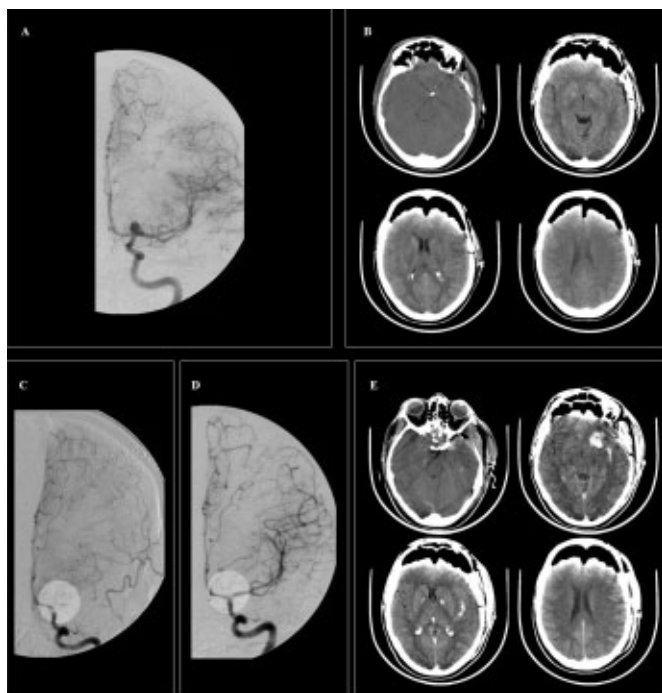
A) Cerebral angiography confirming the presence of an aneurysm of the left internal carotid artery ; B) Urgent post-operative CT-scan showing no hemorrhage or acute sign of ischemia. C) Immediate angiography showing a subocclusive thrombus in the left terminal ICA extending in the M1 segment and an occlusive embolus distally in the left MCA. D) Satisfactory repermeabilization of the left terminal ICA and M1 segment following thrombolysis. E) CT-scan performed immediately after thrombolysis revealing left fronto-orbital and lentiform hemorrhages and mild left Sylvian subarachnoid hemorrhage not requiring surgical treatment.
